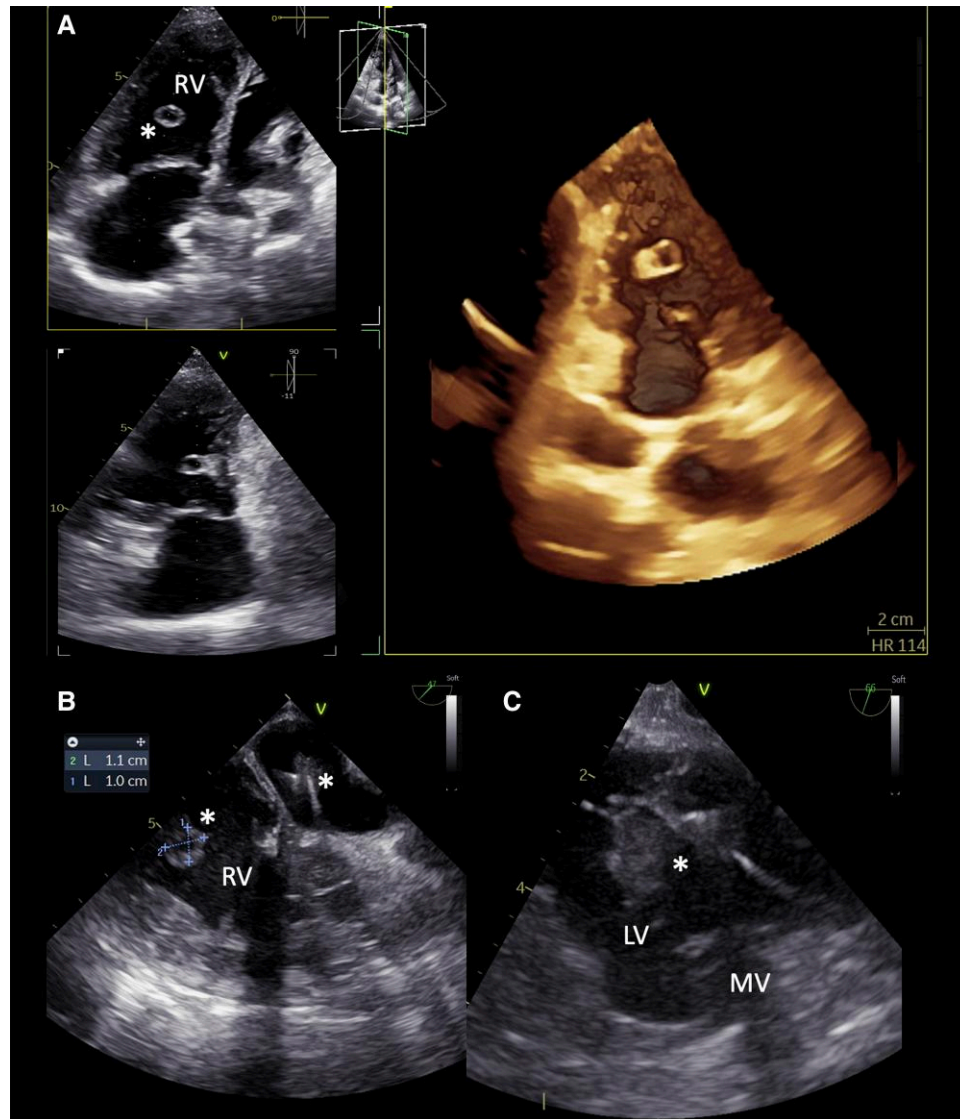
Advanced echocardiography and transoesophageal echocardiography allow a better definition of intracardiac masses. A) Multiplane and 3D echocardiography clarified the extension of the rounded shaped formation, showing that it was in continuity with the papillary muscle. B) Transoesophageal echocardiography midoesophageal four-chamber view showing bilateral presence of vegetations. C) Transoesophageal echocardiography transgastric view with a 60° angle, focused on the left ventricle allowed complete visualization of the pacemaker lead with multiple vegetations. MV, mitral valve; LV, left ventricle; RV, right ventricle; asterisks, vegetations/abscess.
